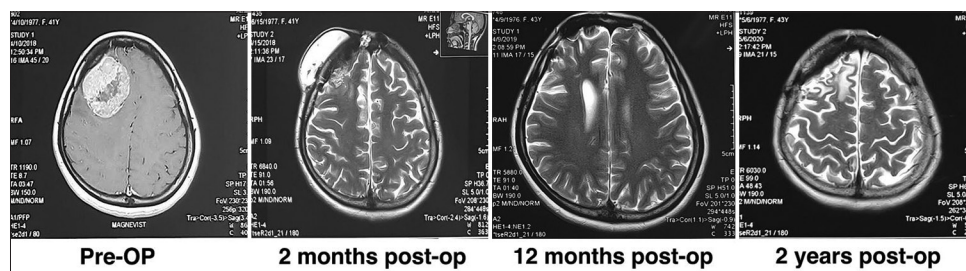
Magnetic resonance imaging demonstrated the spontaneous resolution of the pseudomeningocele after frontal meningioma resection Pre-OP: preoperative; post-op: postoperative
